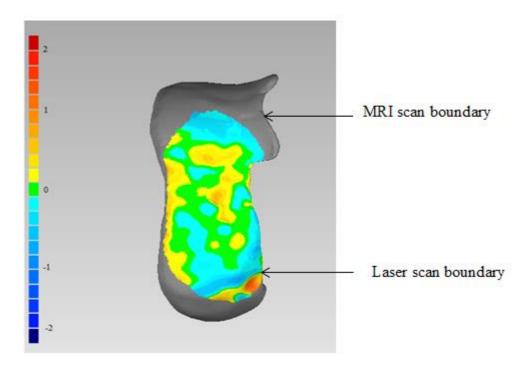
Top view of the colour deviation map showing spatial distribution of the deviations between MRI and laser scan of right femoral lateral cartilage
